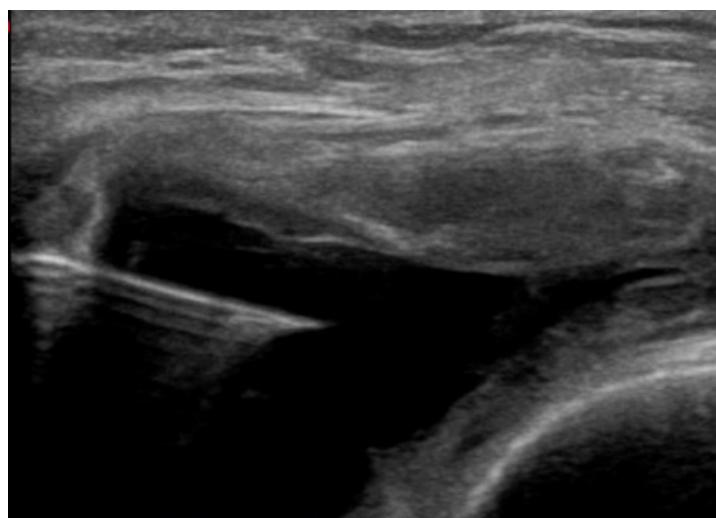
Ultrasound-Guided Aspiration of Knee Joint Effusion Before Intra-Articular Injection of 25% Hypertonic Dextrose
